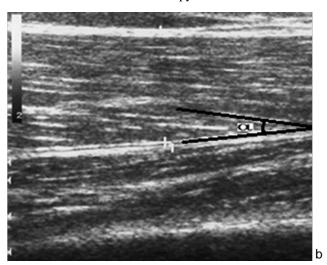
Preoperative (a) and postoperative (b) ultrasound image of musculus rectus femoris and musculus vastus intermedius of a 22-year-old male patient showing pennation angle (α)
